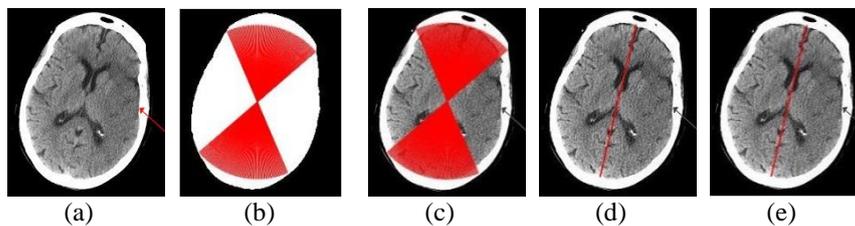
Extracted mid-sagittal plane from T1-Weighted MRI brain axial slice. (a) Original image, (b) Binary image with Filling holes, with indicated the set of equal intensity longer lines by red lines, (c) Greyscale image with indicated the set of longer intensity lines, (d) Select midline from set lines, (e) Optimize the position of the plane by applying left and right shifting respectively.
